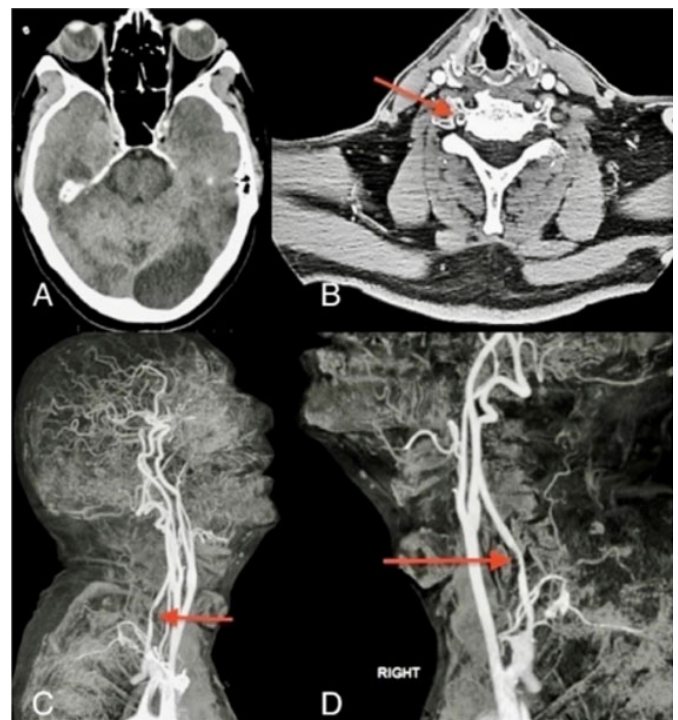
Non-contrast computed tomography (CT) of the patient shows the left occipital nonhemorrhagic infarct (A). Image B is axial CT angiography (CTA) image showing the free-floating thrombus in the right vertebral artery (red arrow). Images C and D show sagittal CTA images of the right vertebral FFT (red arrows).
